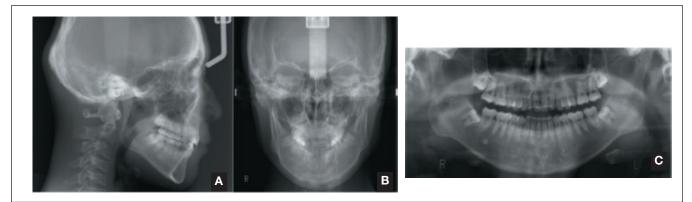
Three-year posttreatment radiographs; A, lateral cephalogram; B, posterioanterior cephalogram; C, panoramic radiograph.
